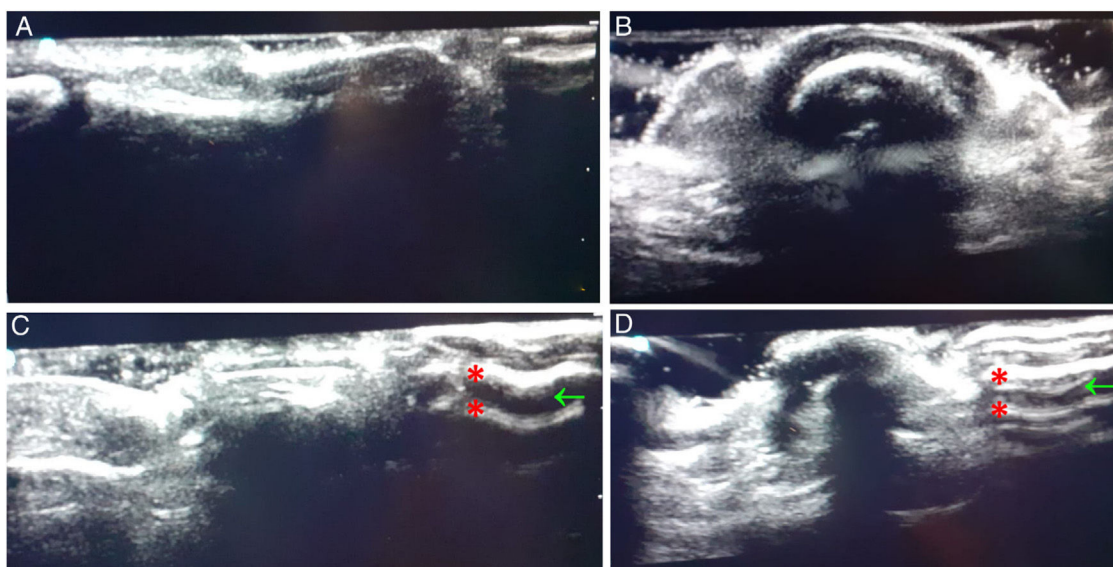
Comparison of ultrasound appearance of the first two toes. Longitudinal (A) and transversal (B) views of the healthy nail compared to the longitudinal (C) and transversal (D) nail involved in retronychia. We can see two superimposed nail plates (*), characteristic of retronychia, with a hypoechoic space in between (arrow).
